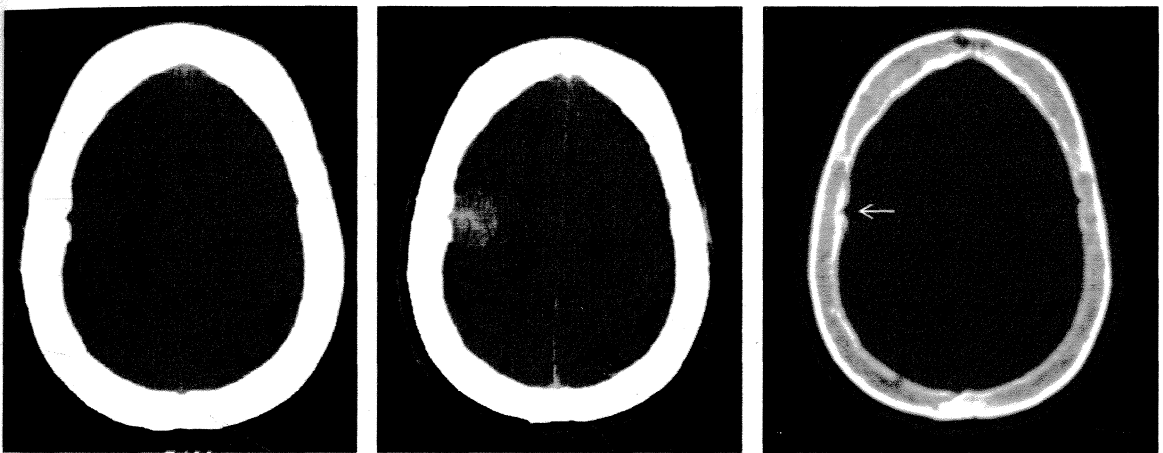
CT scan of a right frontal mid-convexity meningioma showing contrast enhancement and hyperostosis (white arrow)
